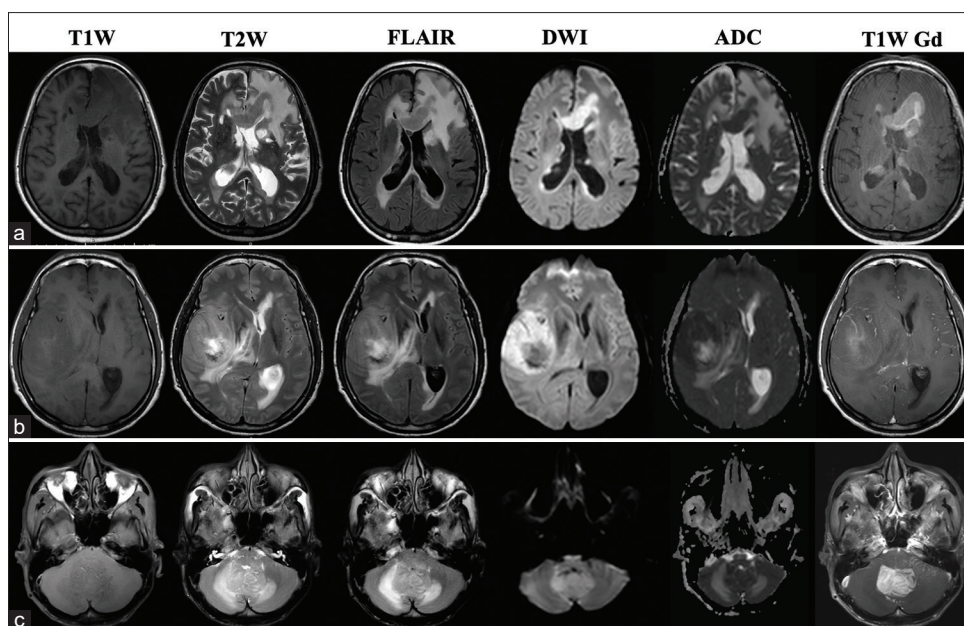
Demonstration of three primary central nervous system lymphoma patients. (a) The MRI finding of typical primary central nervous system lymphoma. Tumors located at corpus callosal, periventricular, and subependymal. On T1W found hypointense, T2W and FLAIR are iso- to hyperintense, DWI is restricted, ADC is hypointense, and T1W gadolinium-enhanced image are homogeneous. This patient underwent a stereotactic biopsy for tissue diagnosis. (b and c). The MRI of non-typical cases of primary central nervous system lymphoma who received craniotomy for tumor removal. (b) They demonstrate a right temporal mass with central Gd enhancement. (c) They show posterior fossa tumor with heterogeneous enhanced
